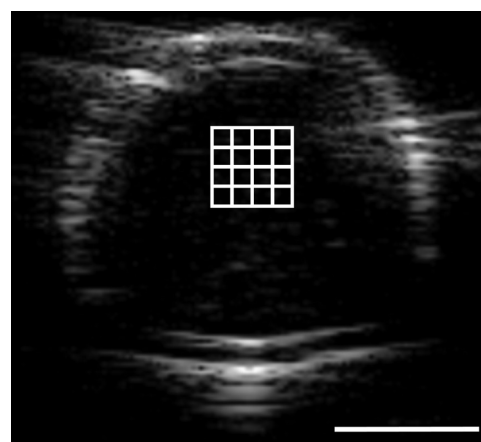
Ultrasound image depicted with the subsectioned ROI used for signal analysis.
